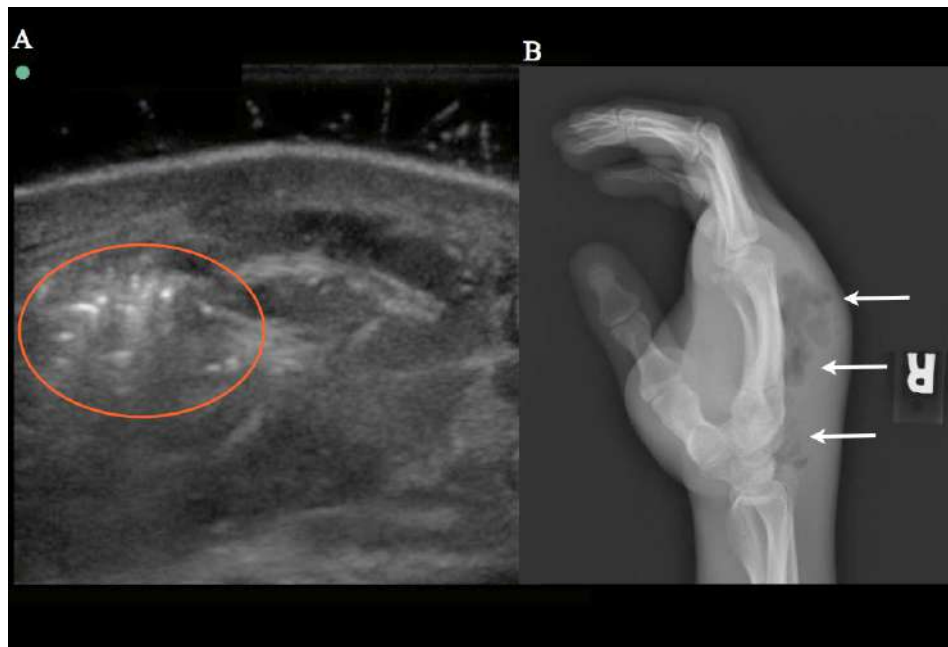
Ultrasound with water bath and radiograph of a patient with necrotizing fasciitis of the hand due to intravenous drug use. (A) Transverse ultrasound view of the right hand with echogenic air (red circle) within the soft tissue. (B) Lateral radiography of the right hand with extensive soft tissue swelling and air within the dorsum of the hand (arrows).
